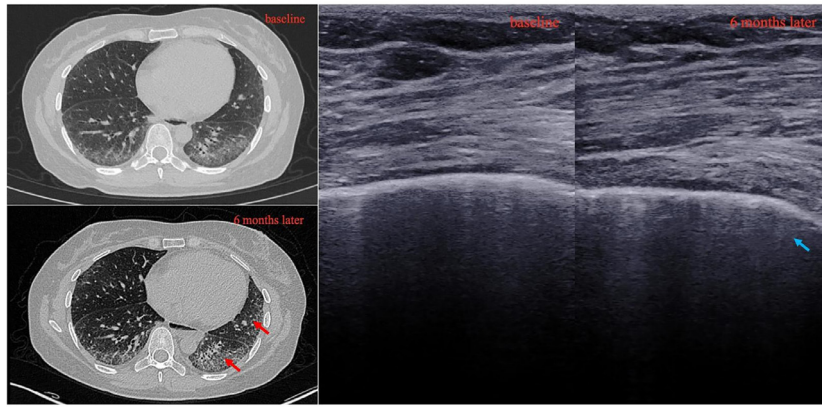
Comparison of LUS and HRCT of a follow-up patient before and after 6 months.
